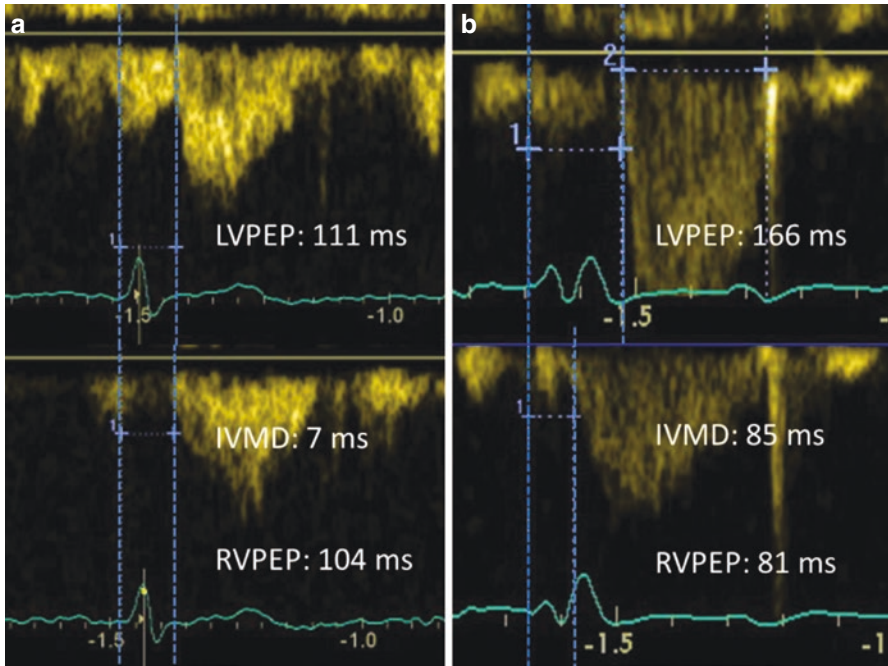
Pulsed-wave Doppler representation of pulmonary valve and transaortic valve flow with indication of left ventricular pre-ejection period (LVPEP), right ventricular pre-ejection period (RVPEP), and interventricular mechanical delay (IVMD) from a healthy individual (panel a) and a patient with severe systolic heart failure and QRS prolongation (panel b)
